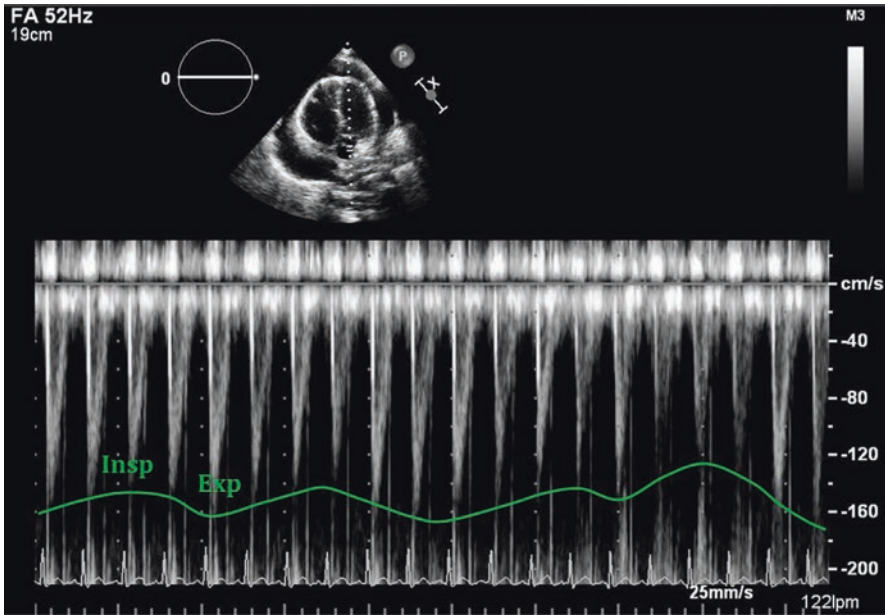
Doppler assessment across left ventricular outflow tract (LVOT) showing significant variation during inspiration and expiration
